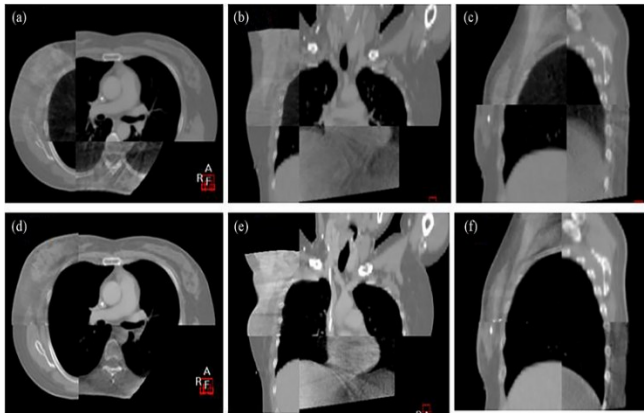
Multi-Planar CT Comparison of Free Breathing (FB) and Deep Inspiration Breath-Hold (DIBH) Scans. (a–c) FB CT images in axial (a), coronal (b), and sagittal (c) views showing the natural positioning of the heart and lungs during normal respiration. (d–f) Corresponding DIBH CT images in axial (d), coronal (e), and sagittal (f) views demonstrating increased lung expansion and posterior displacement of the heart under breath-hold conditions. These differences underscore the geometric and anatomical advantages of DIBH in minimizing cardiac exposure.
